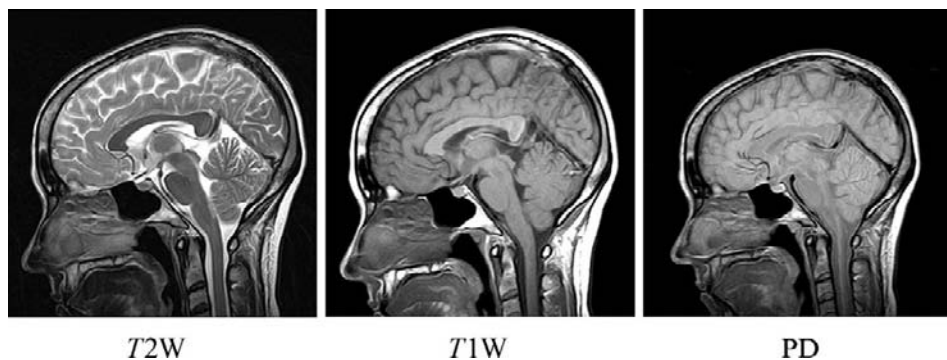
MR images of sagittal brain cross sections using three types of weighting planes: (a) T_2 , (b) T_1 , and (c) proton density. Courtesy of Philips Medical Systems.
